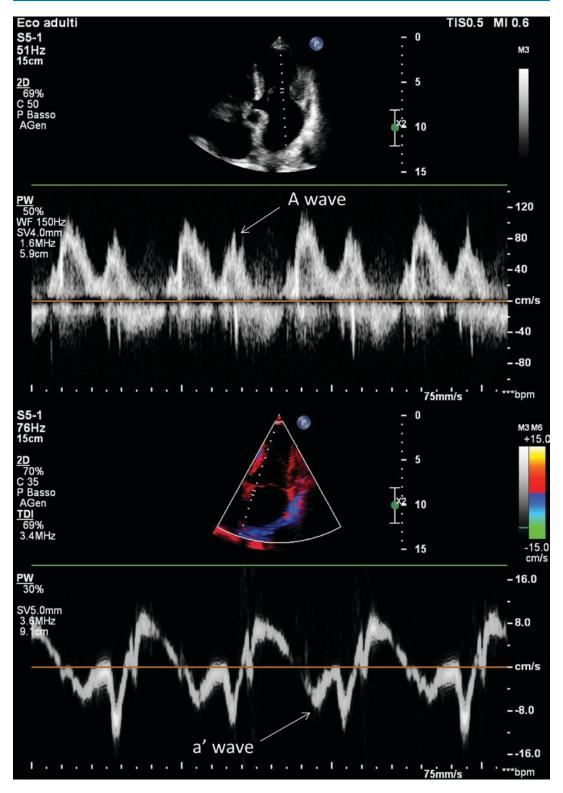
Atrial waves in standard Doppler imaging of mitral inflow (top) and tissue Doppler imaging of mitral annulus motion (bottom)
